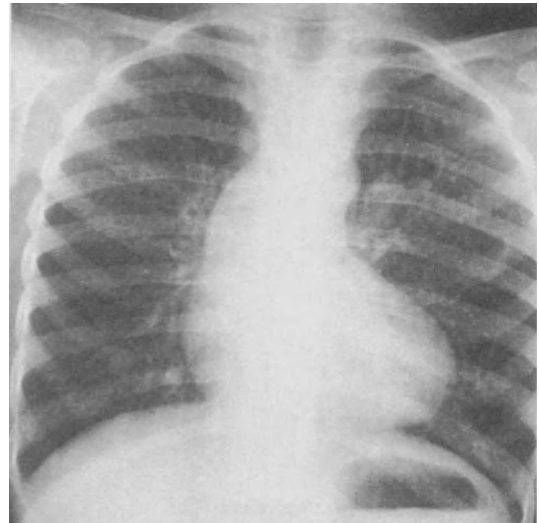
X-ray of the chest in pulmonary atresia. Configuration of the heart is much the same as in Tetralogy of Fallot but there is a lacy pattern in the lung fields produced by bronchial collaterals.
